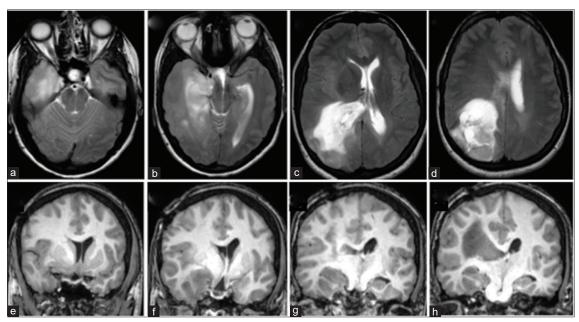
Preoperative magnetic resonance imaging images. Axial (a-d) and coronal (e-h) images show a lesion hyperintense on T2-weighted (T2W) images and isointense on T1-weighted (T1W) images, involving the right medial temporal lobe (a, b, and e-h) and large recurrent tumor involving the right parietal region (c and d).
